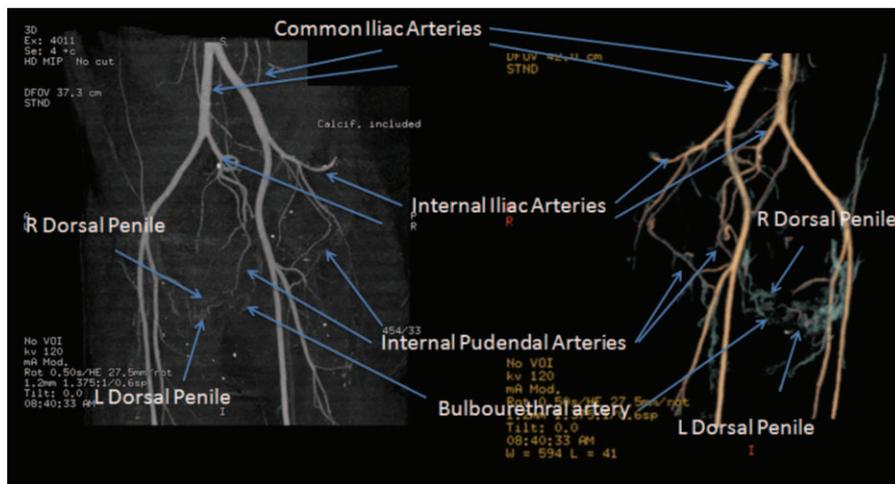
High-resolution CT angiography with 3D reconstruction.
